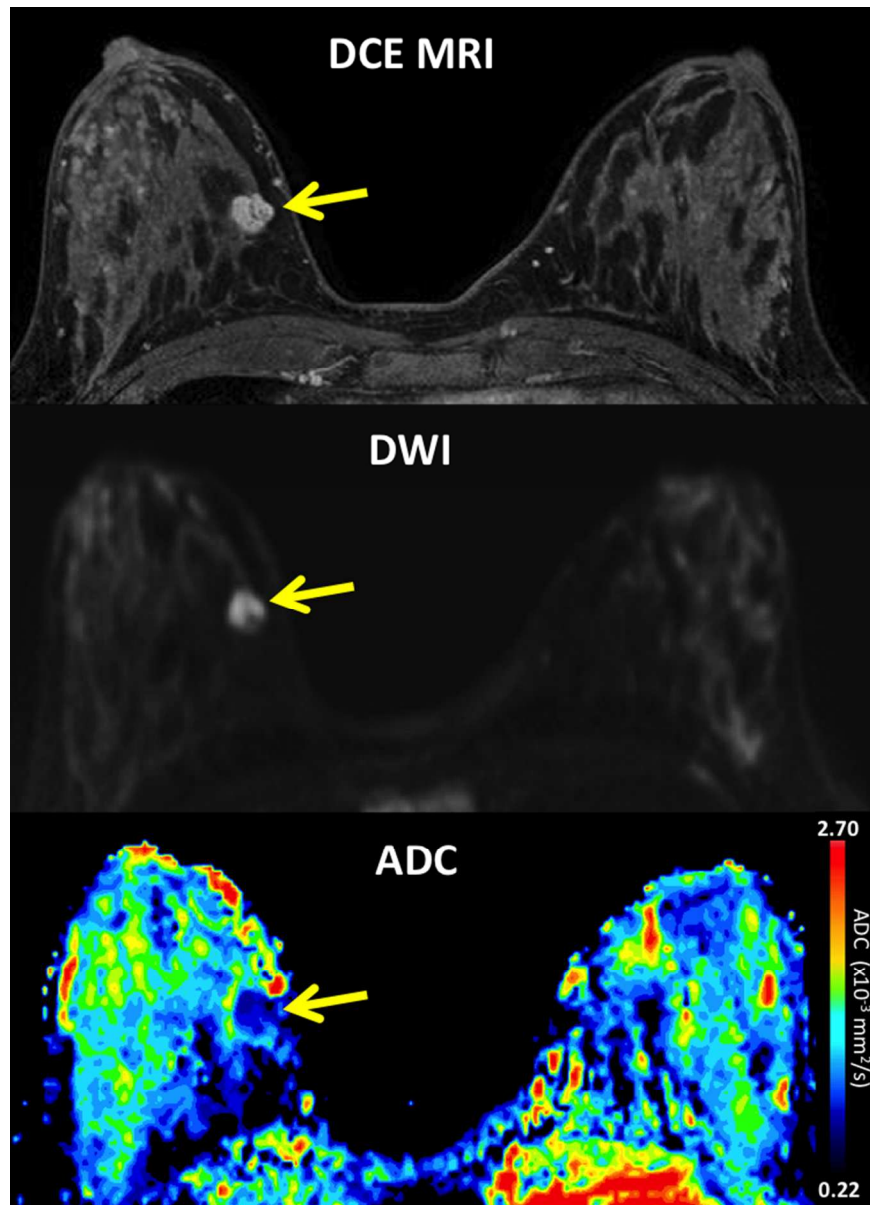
31-year old female with Li-Fraumeni syndrome undergoing breast MRI screening. DCE-MRI demonstrates a mammographically occult mass at 3 o'clock in the right breast (arrow), measuring 11 mm with smooth margins and internal septations, rapid enhancement and washout, assessed as BI-RADS category 4. The lesion exhibits restricted diffusion on DWI, with bright signal compared to adjacent parenchyma on b 800 s/mm² (arrow) and low ADC of 1.15×10^{-3} mm²/s. Ultrasound-guided biopsy revealed malignant phyllodes tumor.
